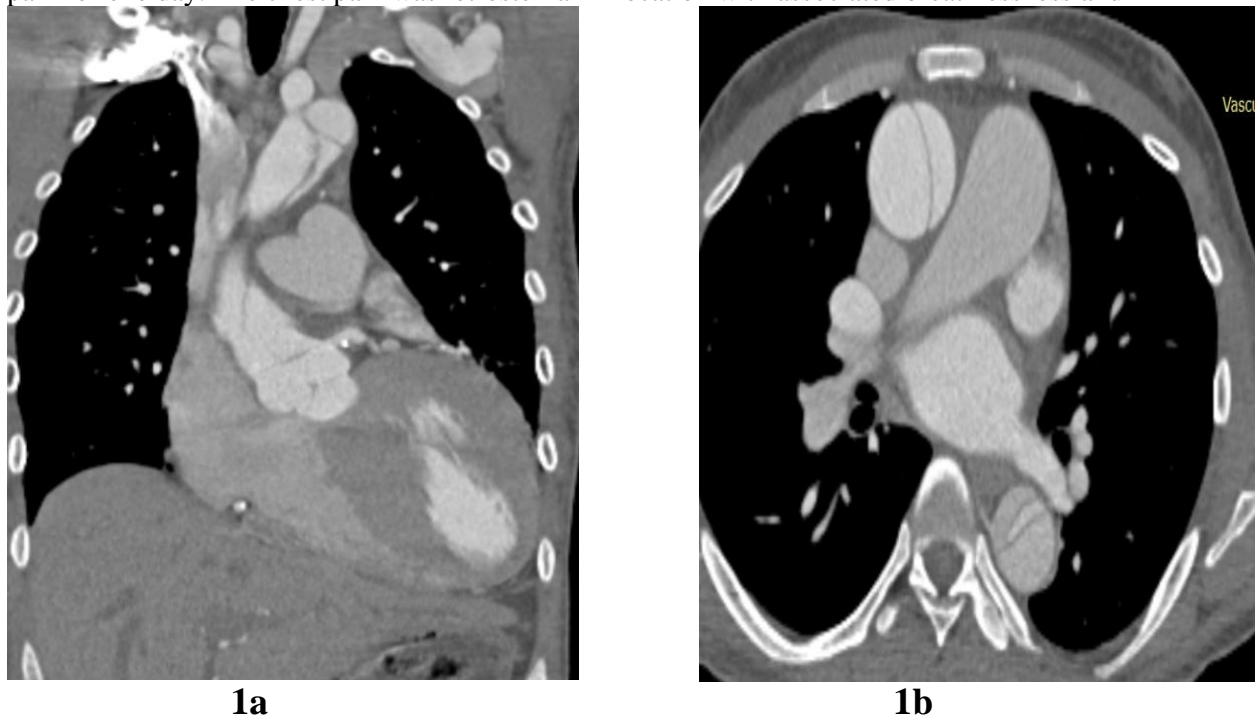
CT angiography images show aortic dissection at the level of aortic root (1a) and at the level of ascending and descending aorta (1b).
